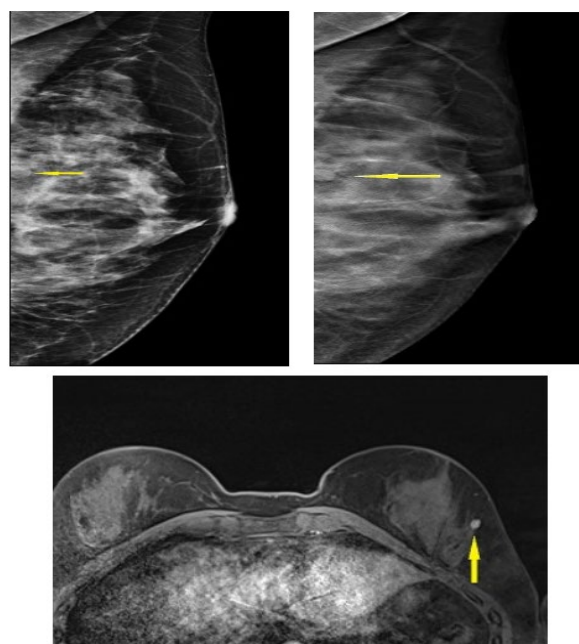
A case of a 34-year old women with dense breasts (ACR D), and HP proven metastasis in left breast from primary neuroendocrine cancer of lung: A) DM and B) DBT in MLO projection images show a small isodense lesion at the junction of the lateral quadrants of left breast, C) MR axial 3D T1W FLASH FS image shows a small solid hyperintense lesion in lateral quadrant of left breast, D) US image shows a hypoechoic nodule in left breast. *Ultrasound images are not available because there is not an archive of ultrasound images at our Institution.
